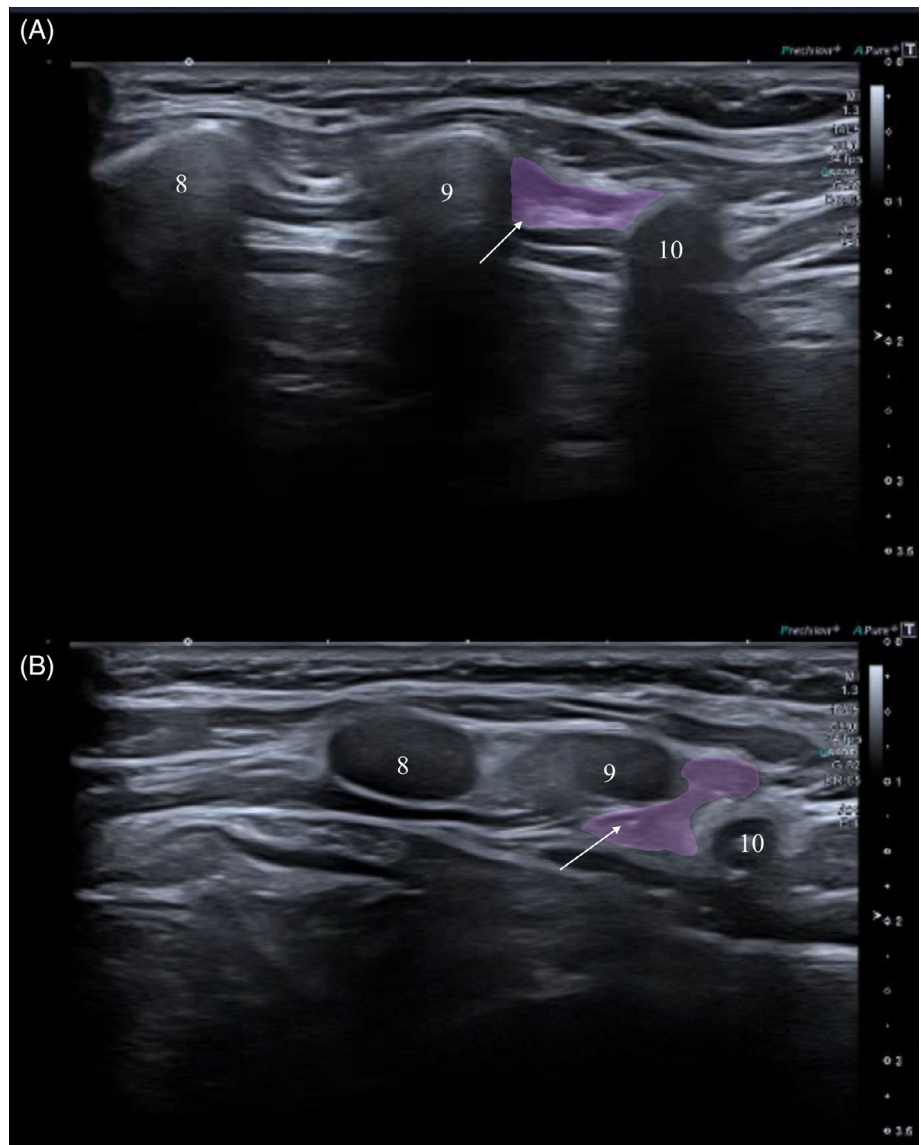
Excessive excursion of the 10th rib in relation to the 9th. A-F, Sagittal ultrasound over the left anterior costal margin. During abdominal flexion, the 10th rib demonstrates posterior and cranial translocation in relation to the 9th rib. Note the normal physiological movement between the 9th and 8th ribs, which remain in line with no subluxation. “10” = tenth rib, “9” = ninth rib, “8” = eight rib
